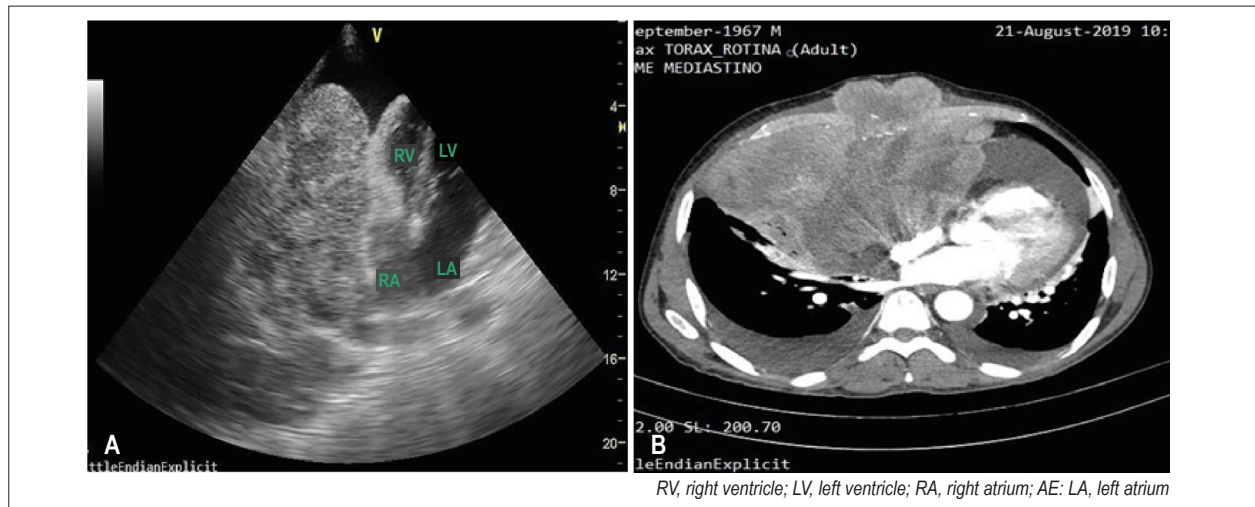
(A) Transthoracic echocardiogram image showing a large pericardial effusion in an expansive process with close contact with the right cardiac chambers, mainly the right atrium. (B) Chest computed tomography image showing a large heterogeneous mass in the lower mediastinum with diffuse contrast medium uptake invading the sternum and the pericardium. The lesion deflects the heart to the left and is compressing the right heart chambers.
